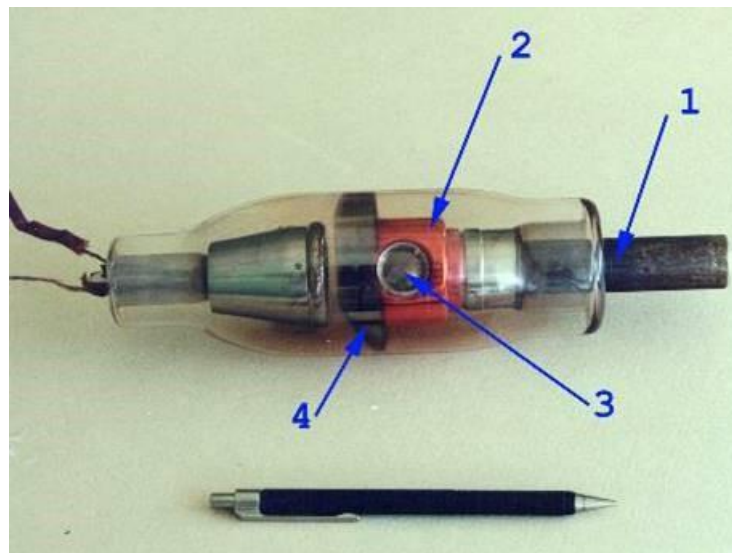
X-ray tube with static anode (low power). 1. Anode stem. 2. Electron capture hood. 3. Beryllium window over the Anode. 4. Metallization of the glass envelope. Courtesy of S. Tabakov (King's College London).
